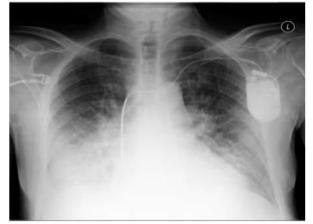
Chest X-ray showing parenchymal congestion related to acute pulmonary edema.
